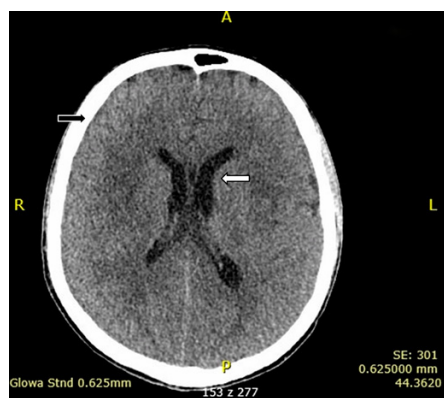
CT scan on the 8th day of hospitalization. The black arrow points to flattened cerebral sulci, suggesting cerebral oedema. The white arrow points to an asymmetrical, enlarged left lateral ventricle. The ventricular system is not displaced
